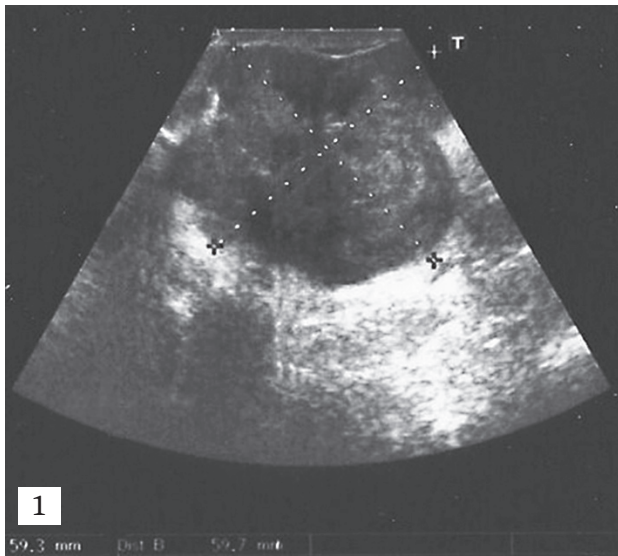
B-mode ultrasound image of the scrotum. (oblique plane).
